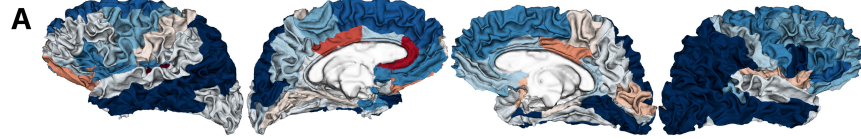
Abbreviations: AD = antidepressant; CVR = coefficient of variation ratio; CT = cortical thickness; FDR = false discovery rate; HC = healthy control; IQR = interquartile range; LH = left hemisphere; MDD = major depressive disorder; PBSI = person-based similarity index; RH = right hemisphere.
